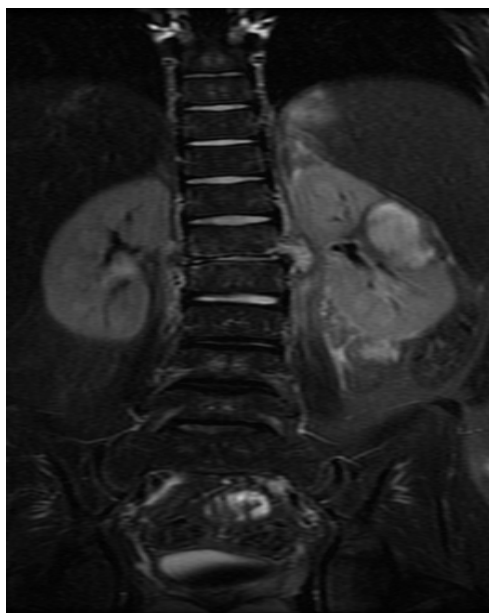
Pelvis MRI 11.02.2014
